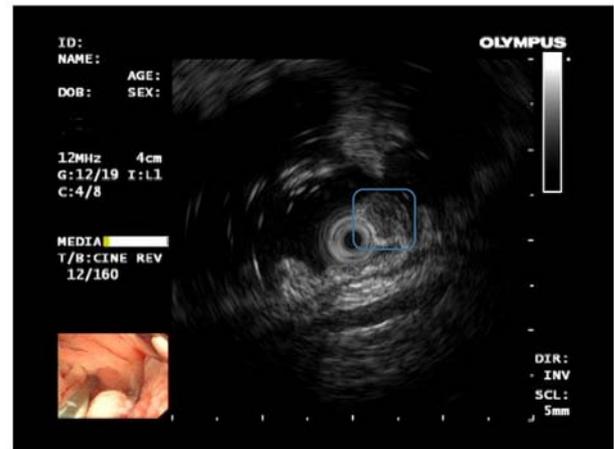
Endoscopic ultrasonography showed that the rectal submucosa had a low echo convex lesion, 0.6-0.8 cm in size. The blue box indicates the location of the convex lesion.
